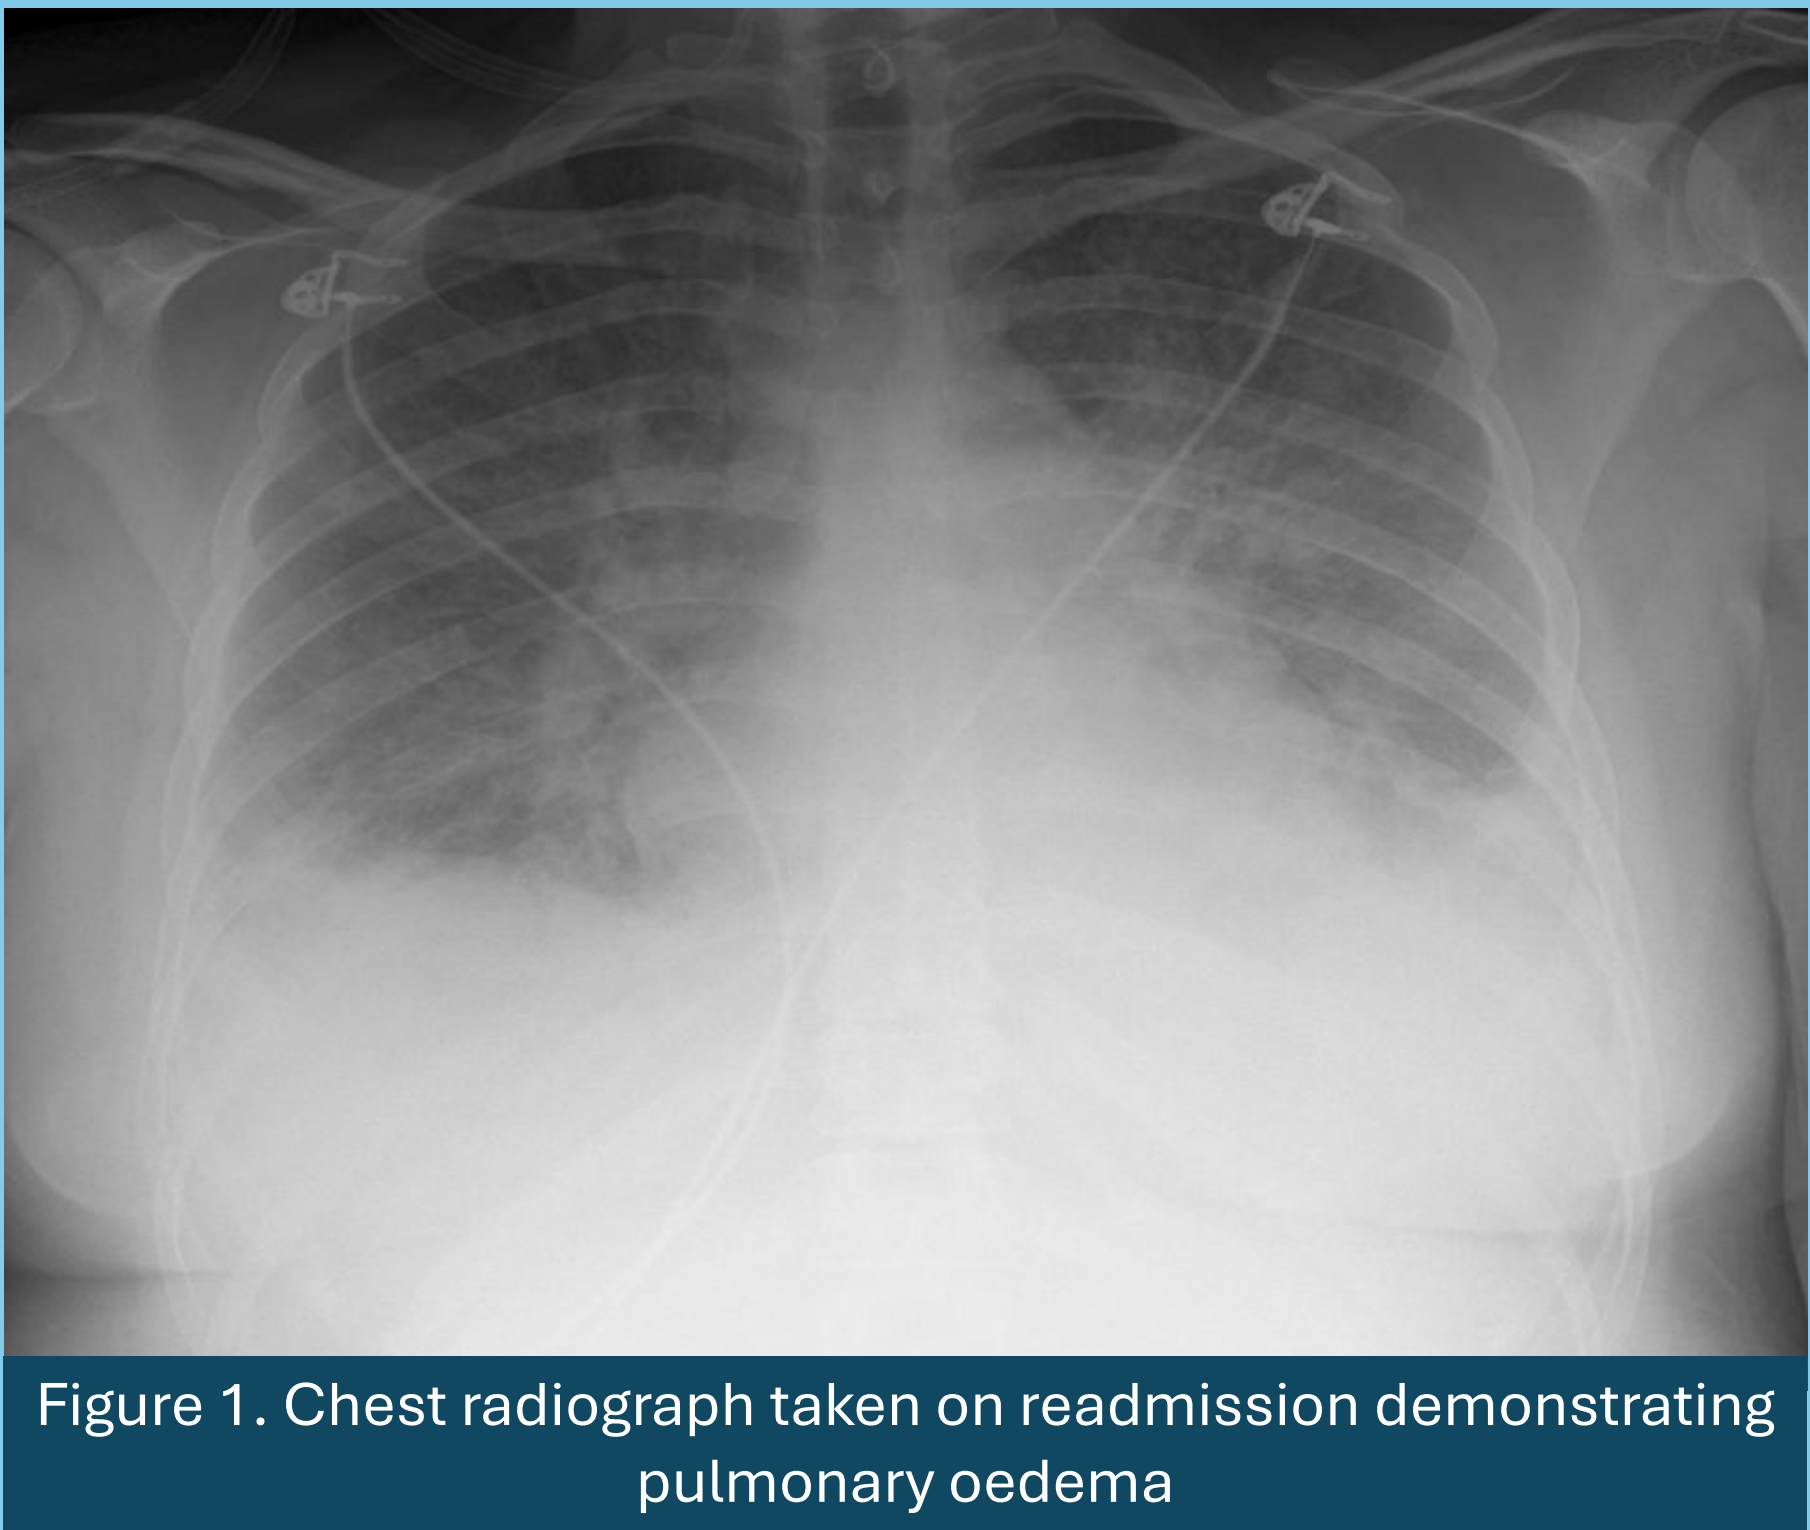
Chest radiograph taken on readmission demonstrating pulmonary oedema
